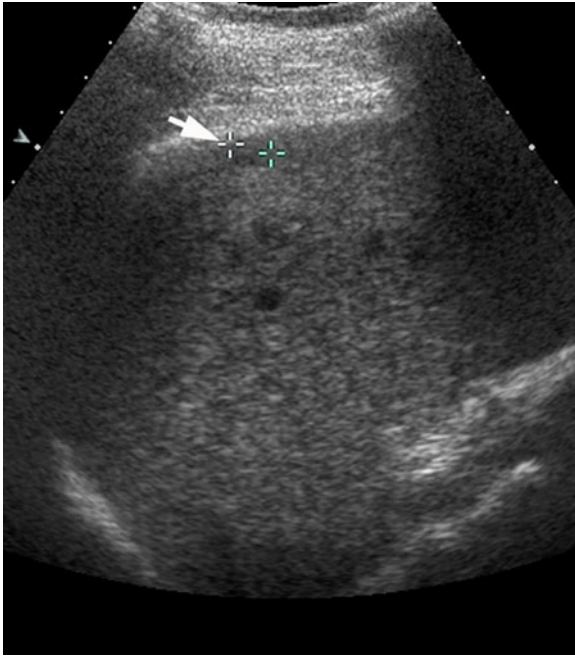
Sonographic study in a cirrhotic patient shows a small subcapsular hypoechoic nodule corresponding to a dysplastic nodule (*arrow*).
